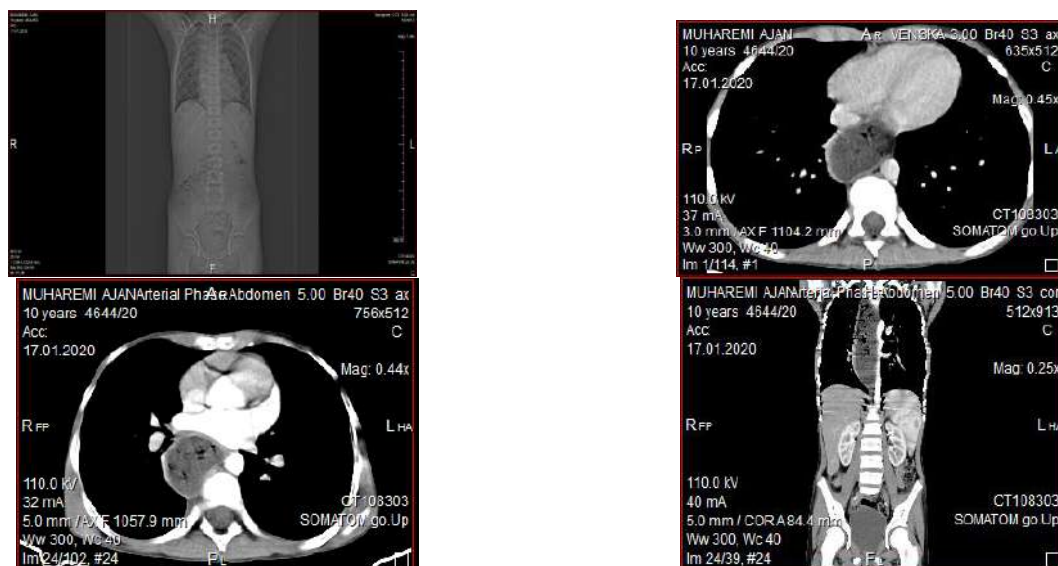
CT of thorax and abdomen
